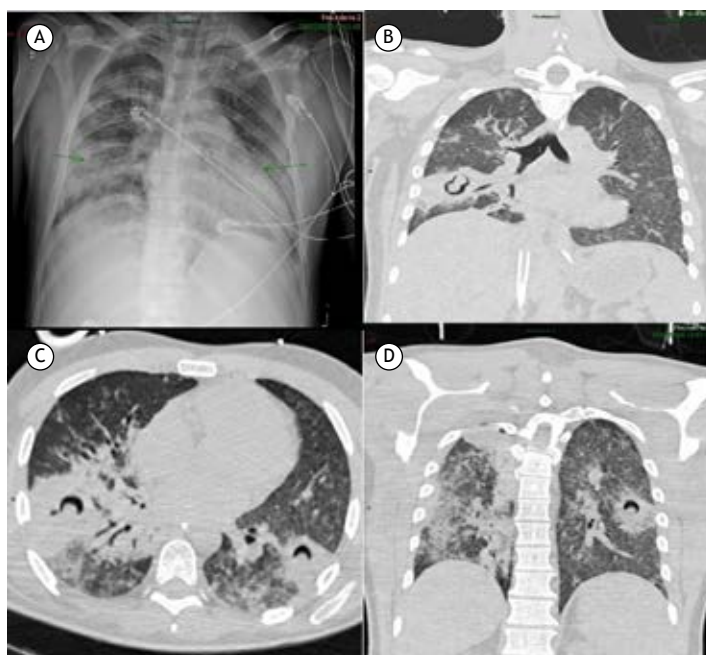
Air crescent sign on chest X-ray (in A) and chest CT scans (in B, C, and D).
